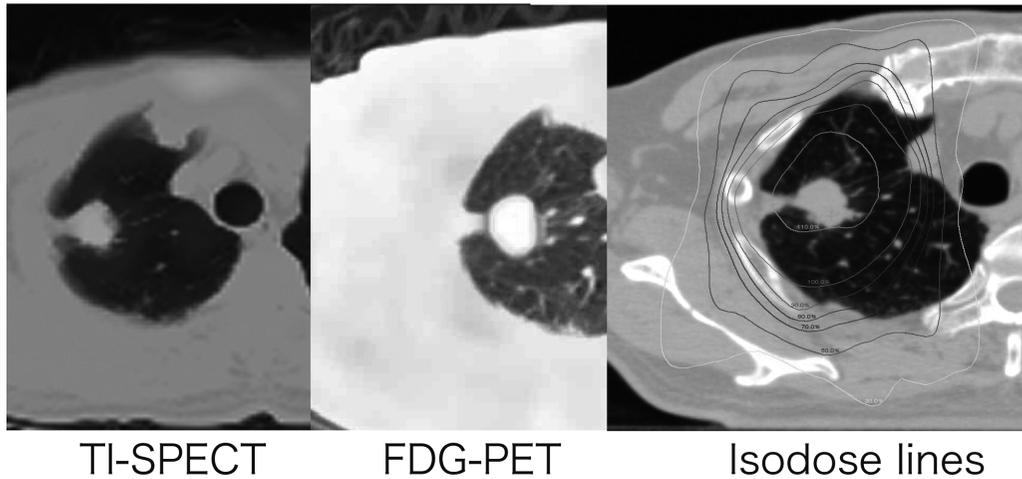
TI-SPECT and FDG-PET scans of the radiation field and a stereotactic radiotherapy dose map obtained in an actual case
